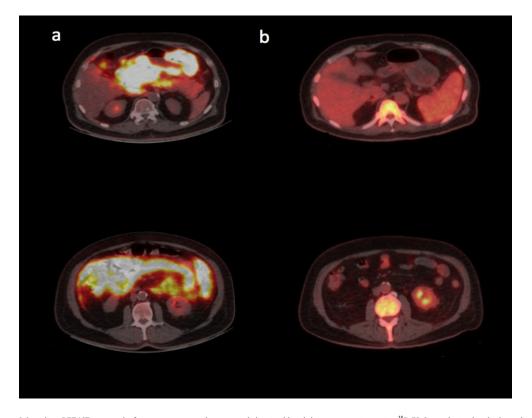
Transaxial, baseline PET/CT images before treatment at the upper abdominal level demonstrate intensive ¹⁸F-FDG uptake in the thickened stomach (SUVmax 27.3) and duodenum along with hypermetabolic nodular masses in the peritoneum, while tracer uptake is suppressed in the liver, spleen and kidneys (a, upper row). PET/CT images at a lower abdominal level reveal diffuse, intensive ¹⁸F-FDG accumulation in almost the entire omentum, mesentery (SUVmax 25.3) and thickened small bowel, consistent with extensive lymphomatous involvement (a, lower row). After treatment, the respective PET/CT images at the upper and lower abdominal levels reveal CMR of the previously infiltrated organs, normalization of the ¹⁸F-FDG activity in the liver, spleen and kidneys as well as diffuse enhanced uptake in the bone marrow and the spleen (b).
